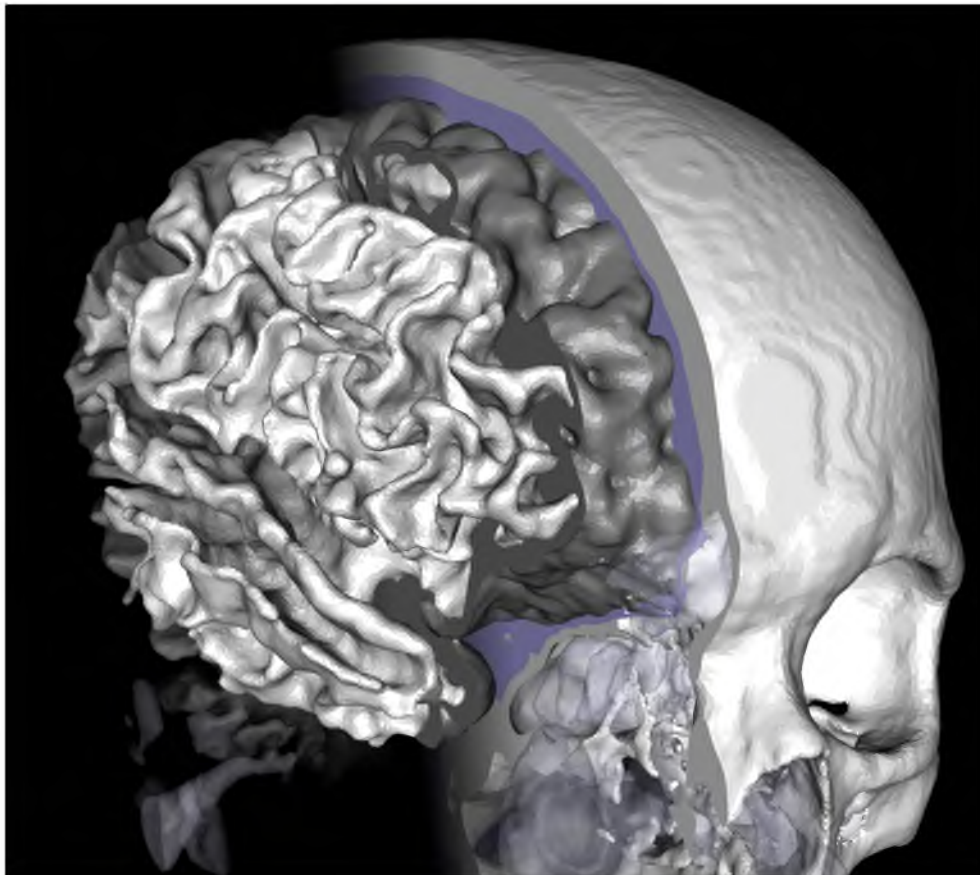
A smooth surface representation of a brain and skull. A variational meshing algorithm, Biomes3D, produced the smooth surface representations of the brain, white and grey matter, CSF, and skull based on an MRI image of a head. Some of the tissues are clipped away in order to visualize the inner tissues.
